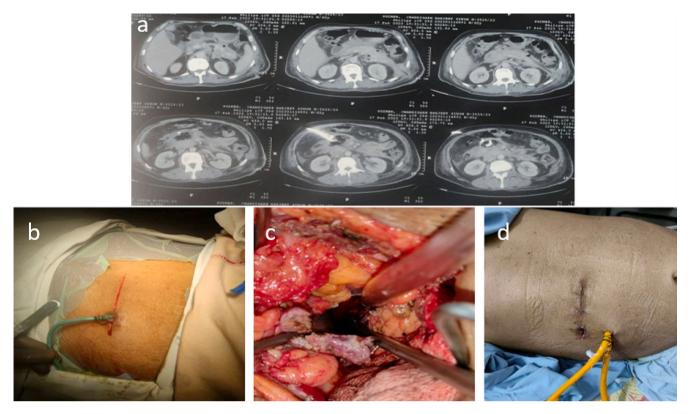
a)Preoperative CT images with WON with pigtail in situ. b)Incision along the pigtail. c) WON cavity. d) Healed scar with drainage Foley catheters.
